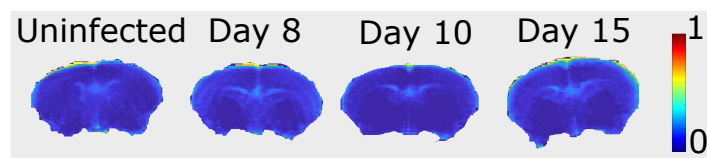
CE-MRI images produced for comparison with DWASL-EPI
